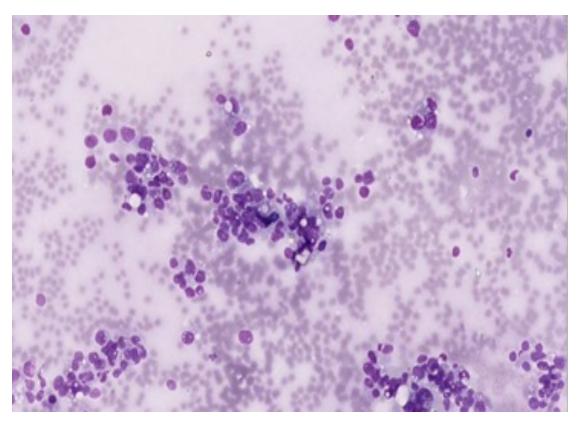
Endoscopic ultrasound guided fine-needle
